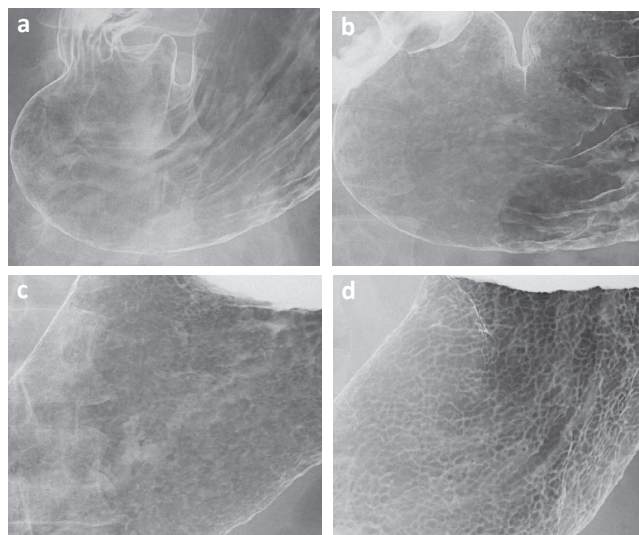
Typical Images of the Gastric Mucosal Surface of Chronic *Helicobacter pylori* Gastritis by Double-contrast Upper Gastrointestinal Radiography
